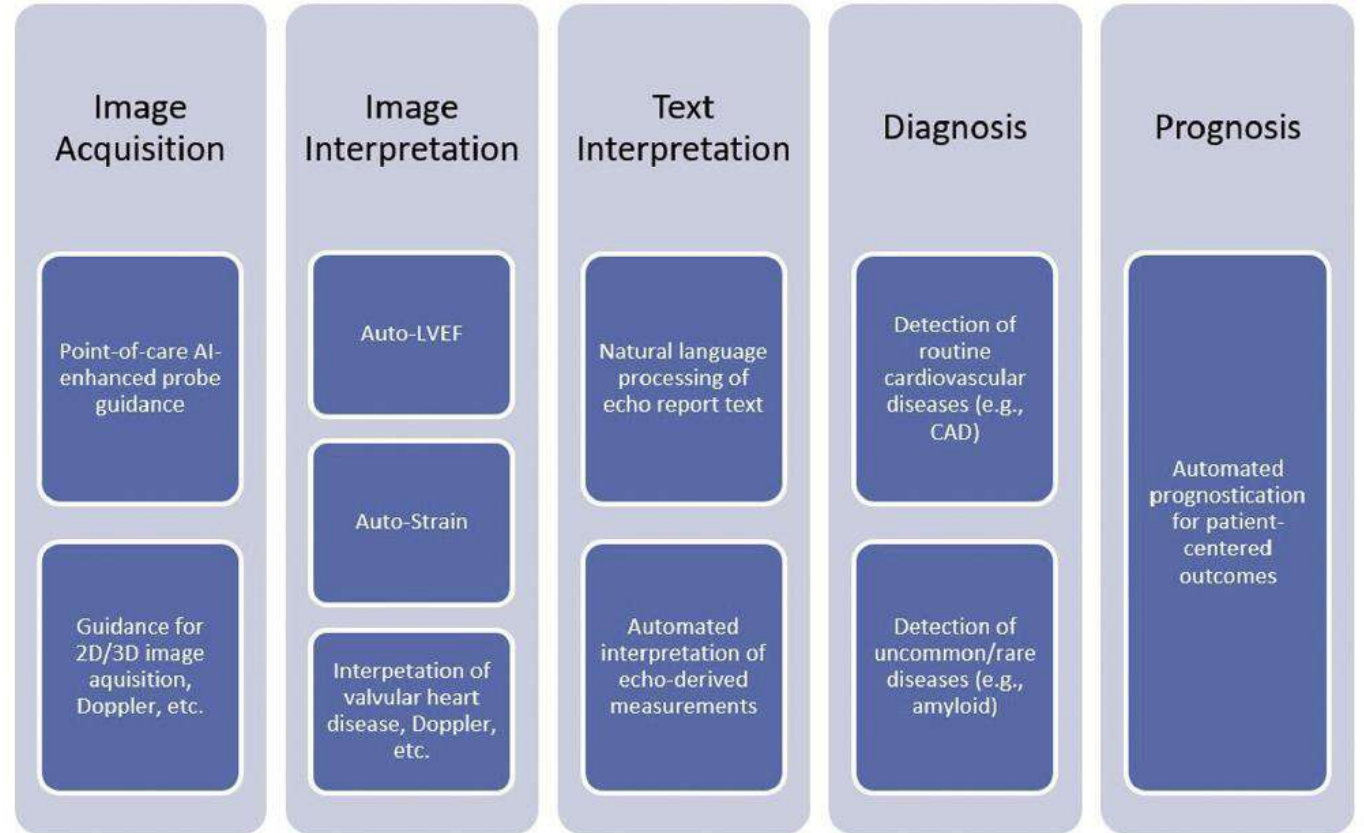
Current and potential applications of AI in echocardiography. The applications of AI in echocardiography span multiple domains, including image acquisition, image interpretation, text interpretation, diagnosis, and prognosis.
